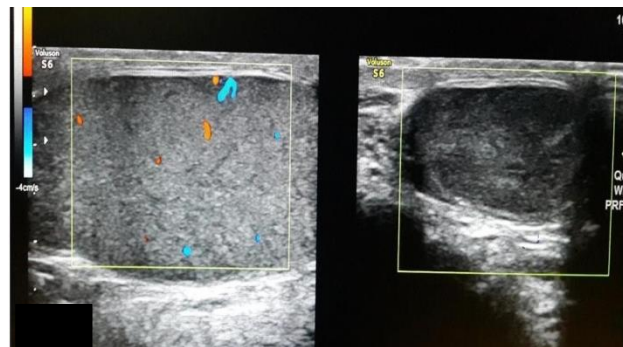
An ultrasonography image with color Doppler shows difference in vascularity of normal testicle (on left) and atrophied testicle (on right).
